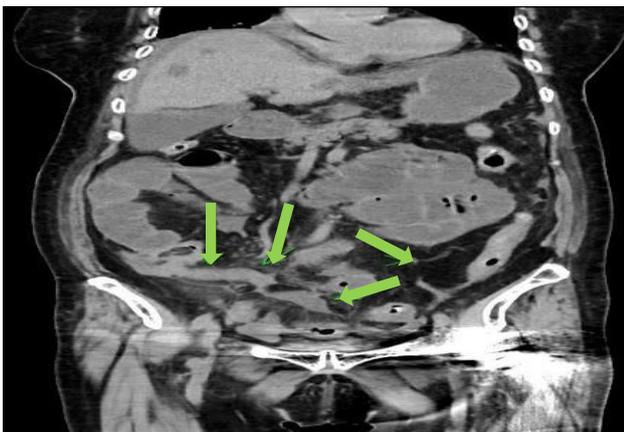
CT imagine on admission, coronal; dilated bowel loops of small bowel, (decompressed terminal ileum green arrows patient right, center green arrow fluid collection, left green arrowhead atherosclerotic plaque).
